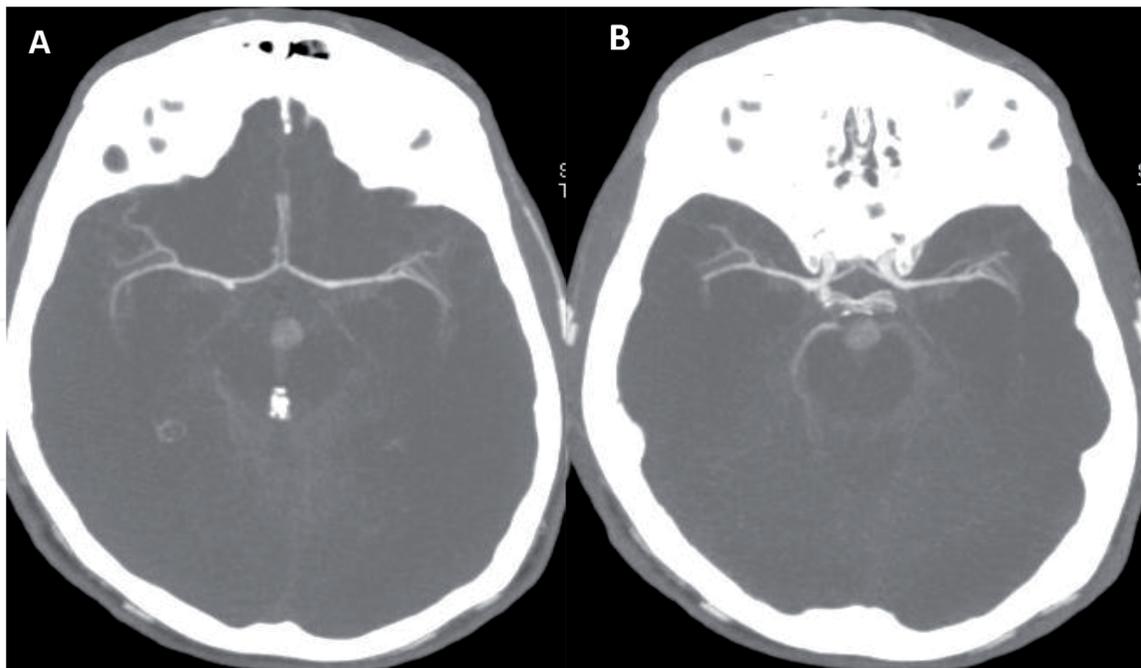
Axial CTA images (A, B) in patient with clinically confirmed brain death show contrast opacification of bilateral internal carotid arteries, proximal branches of bilateral middle, and anterior cerebral arteries. None of the two images show opacification of M4 or cortical branches of middle cerebral arteries, distal anterior cerebral artery (ACA), internal and great cerebral vein. There is some opacification of only right posterior cerebral artery. There is continued filling of the extra cranial arteries.
